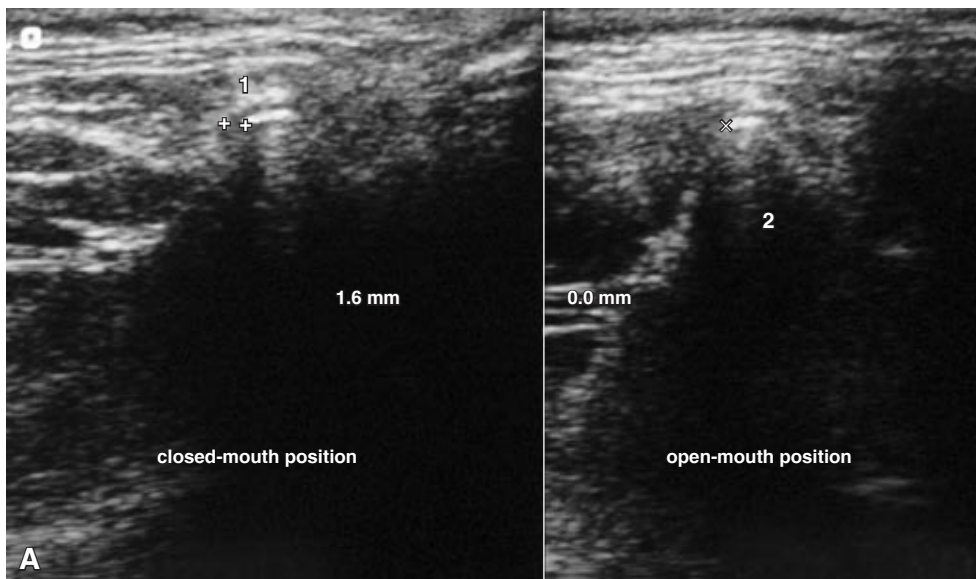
A) Anterior capsule-condyle distance in a transverse (axial) ultrasonographic scan, in the closed- (1 = 1.6 mm) and open-mouth (2 = 0.0 mm) positions. The top of the figure is guided to lateral and the left side to anterior. B) Same image shown in (A), with the contour of the capsule and condyle.
